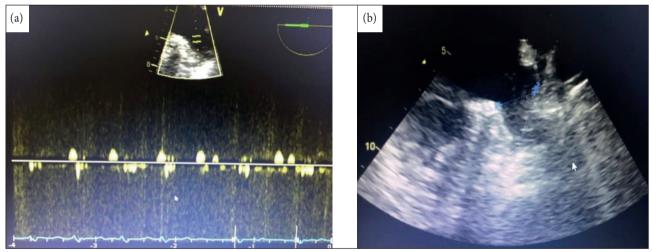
Transesophageal echocardiogram: (a) with Doppler velocity of left atrial appendage (LAA), (b) with "smoke", spontaneous contrast in the left atrium (LA) and LAA, and sparklier image inside LAA.
